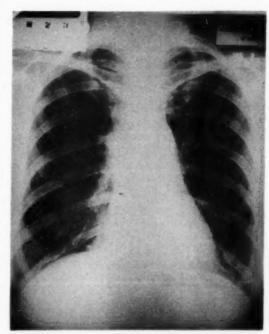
X-ray of chest taken in 1944. This was interpreted as negative.
